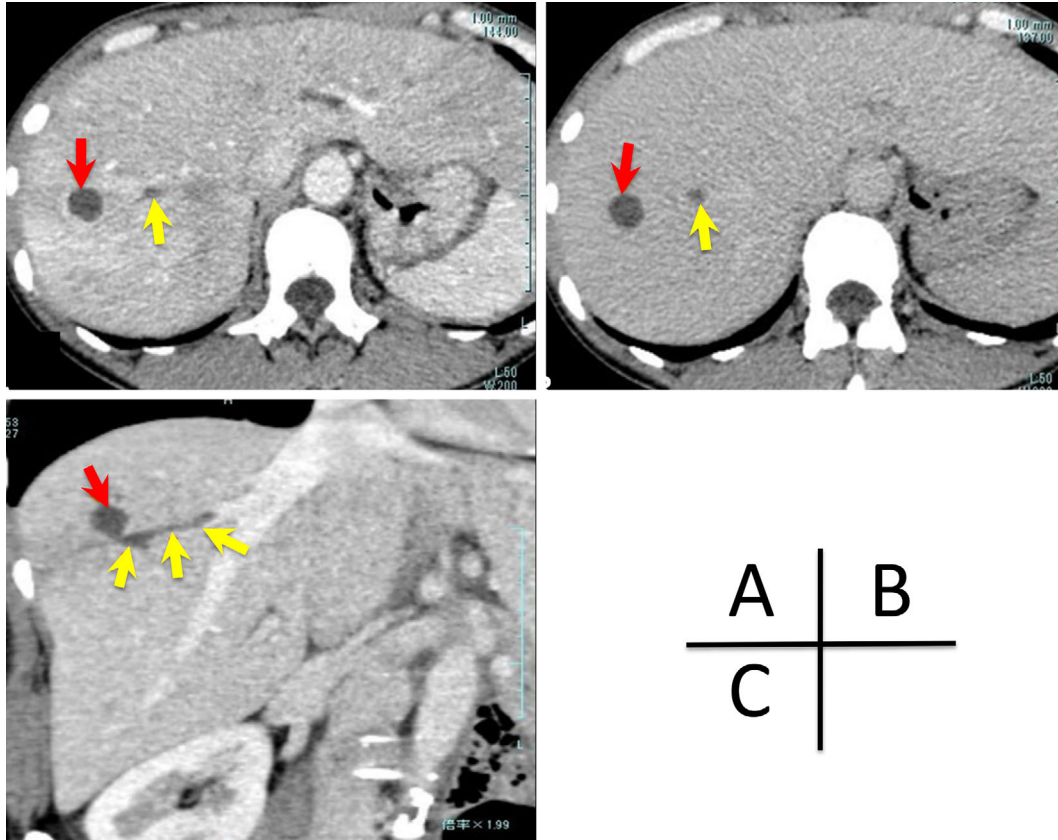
Computed tomography scans of the abdomen demonstrating liver abscesses (red arrows) and hepatic vein thrombus (yellow arrows). A: arterial-dominant phase, B: equilibrium phase, C: portal-dominant phase.
